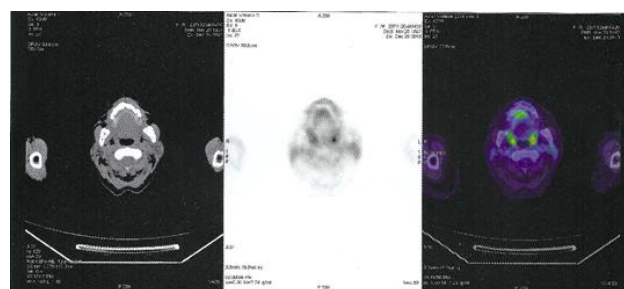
PET-CT – relatively symmetrical capture of the radio transmitter at the level of the tonsils
